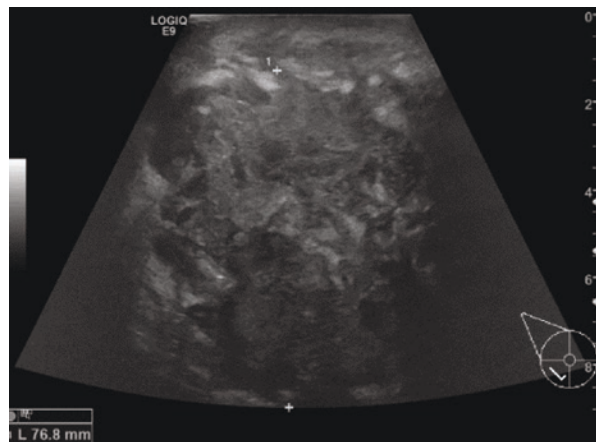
A 26-year-old breastfeeding patient with a 2-week history of mastitis in the right breast. Ultrasound shows a large 70-mm complex collection confirmed to be an infected galactocele
